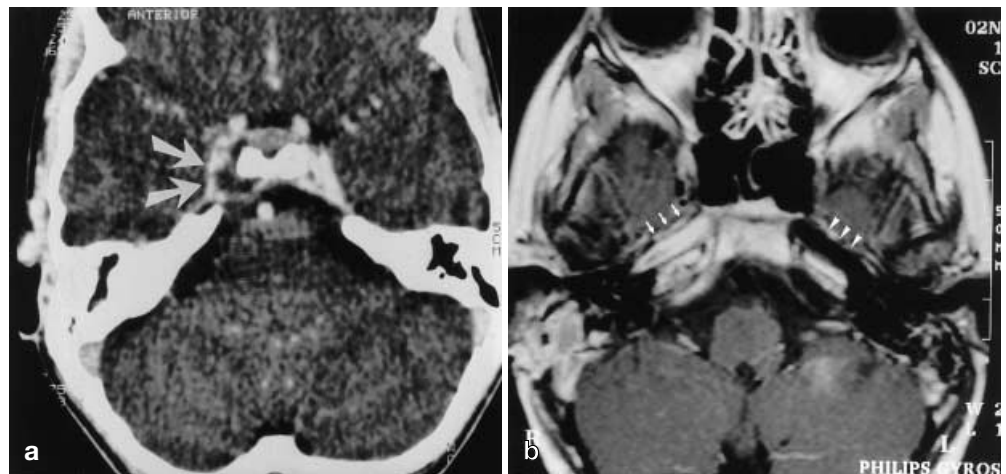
a Computed tomography of a child with mastoiditis. Infection propagated along the superior petrous sinus with septic thrombosis of the right cavernous sinus, visualized as a hypodense filling defect within the right cavernous sinus (*arrows*). b On follow-up, contrast-enhanced MRI showed thrombosis of the internal carotid artery (*arrows*). The contralateral carotid artery shows a normal hypointense flow void (*arrowheads*)
